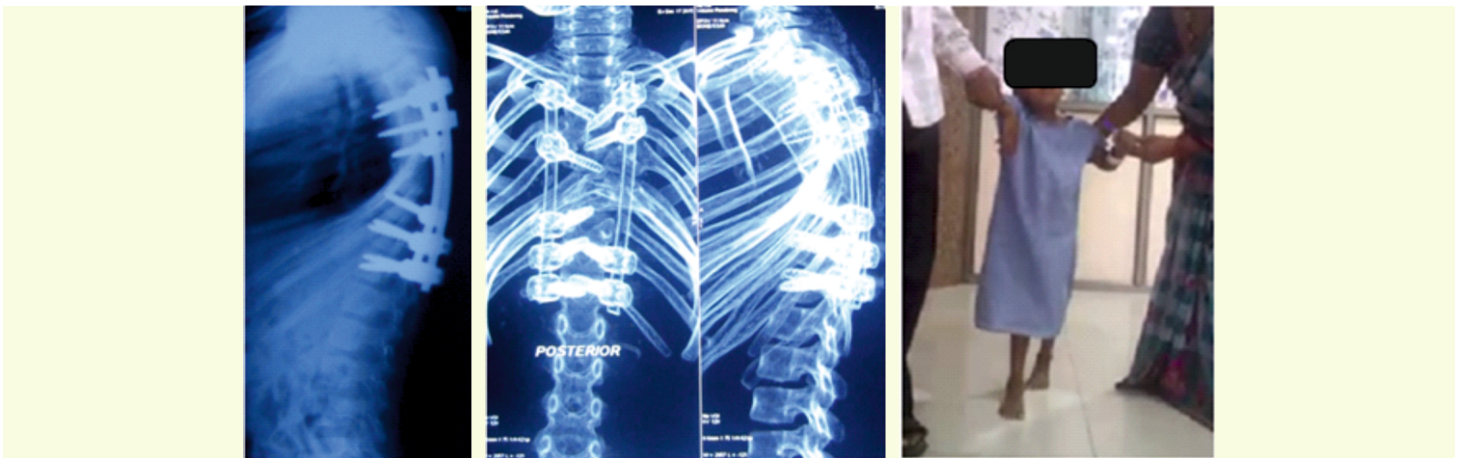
Postoperative radiographs and CT images of case 2 showing kyphosis correction. On the right side the clinical photograph shows the girl walking with support on 3rd postoperative day with improvement in her neurology.
